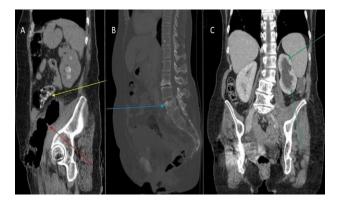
CT imaging demonstrating (A) a large left IPA (red arrow) with contrast loaded colon (yellow arrow), (B) L4 vertebral lesion (blue arrow), and (C) left side hydronephrosis (green arrow).
